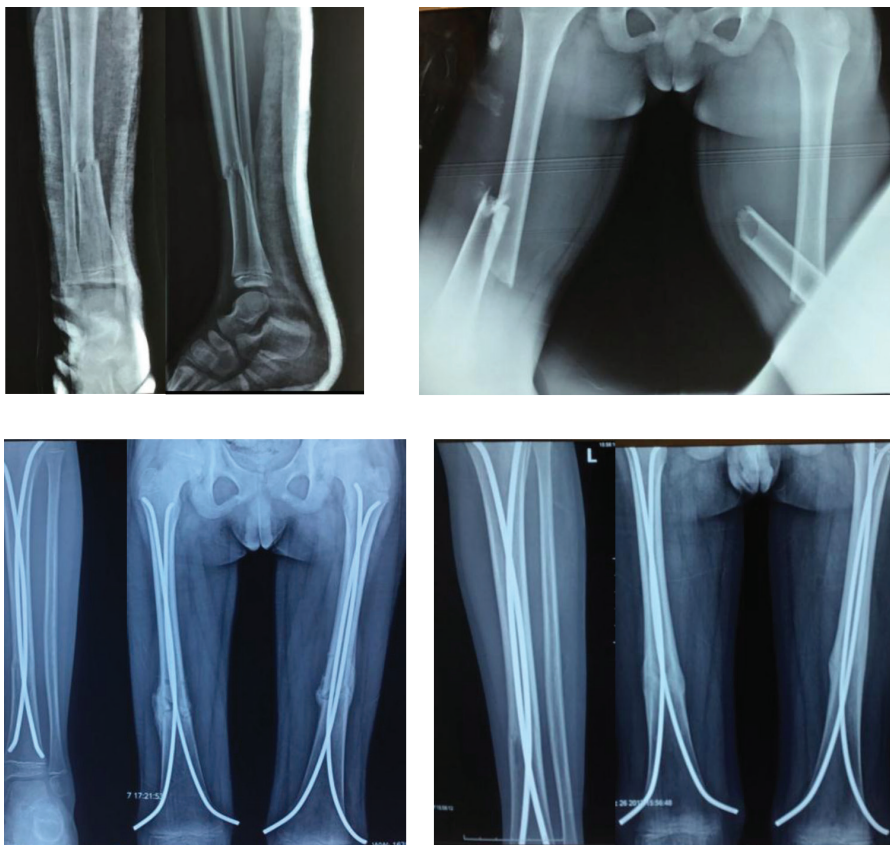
Preoperative and postoperative AP and lateral radiographs.
